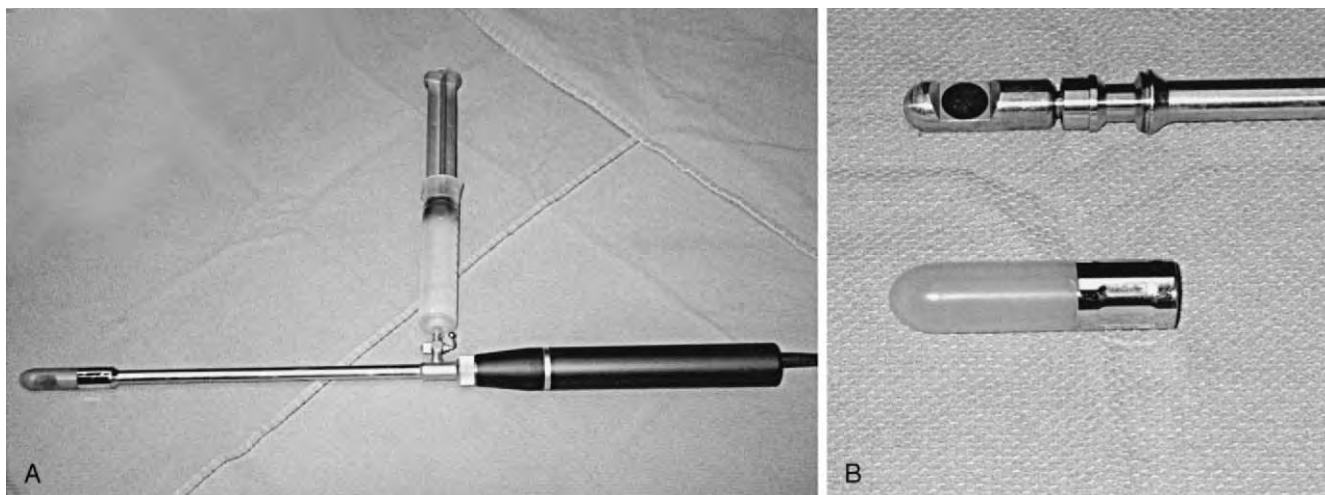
A, Transanal ultrasound probe (type 1850; Brüel and Kjaer, Naerum, Denmark). B, The rotating transducer is covered by a hard plastic sonolucent cone, which is then filled with water to provide an acoustic interphase.
